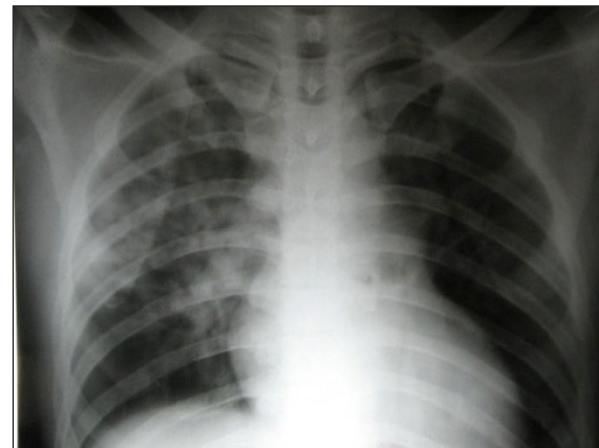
Chest X-ray in a patient of HAPE showing a normal cardiac shadow, characteristic patchy irregular infiltrates in the right middle lung fields with sparing of the apices and areas above the diaphragm. HAPE: High altitude pulmonary edema.
